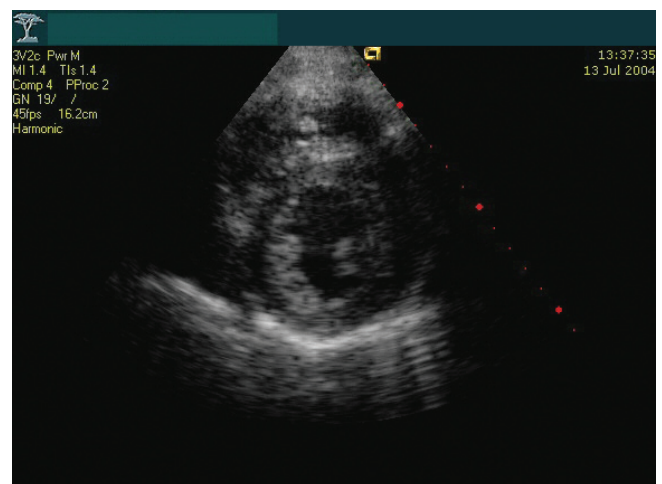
Parasternal short axis view of the left ventricle demonstrating mild concentric hypertrophy, posterior hypokinesia and mild cavity dilation
